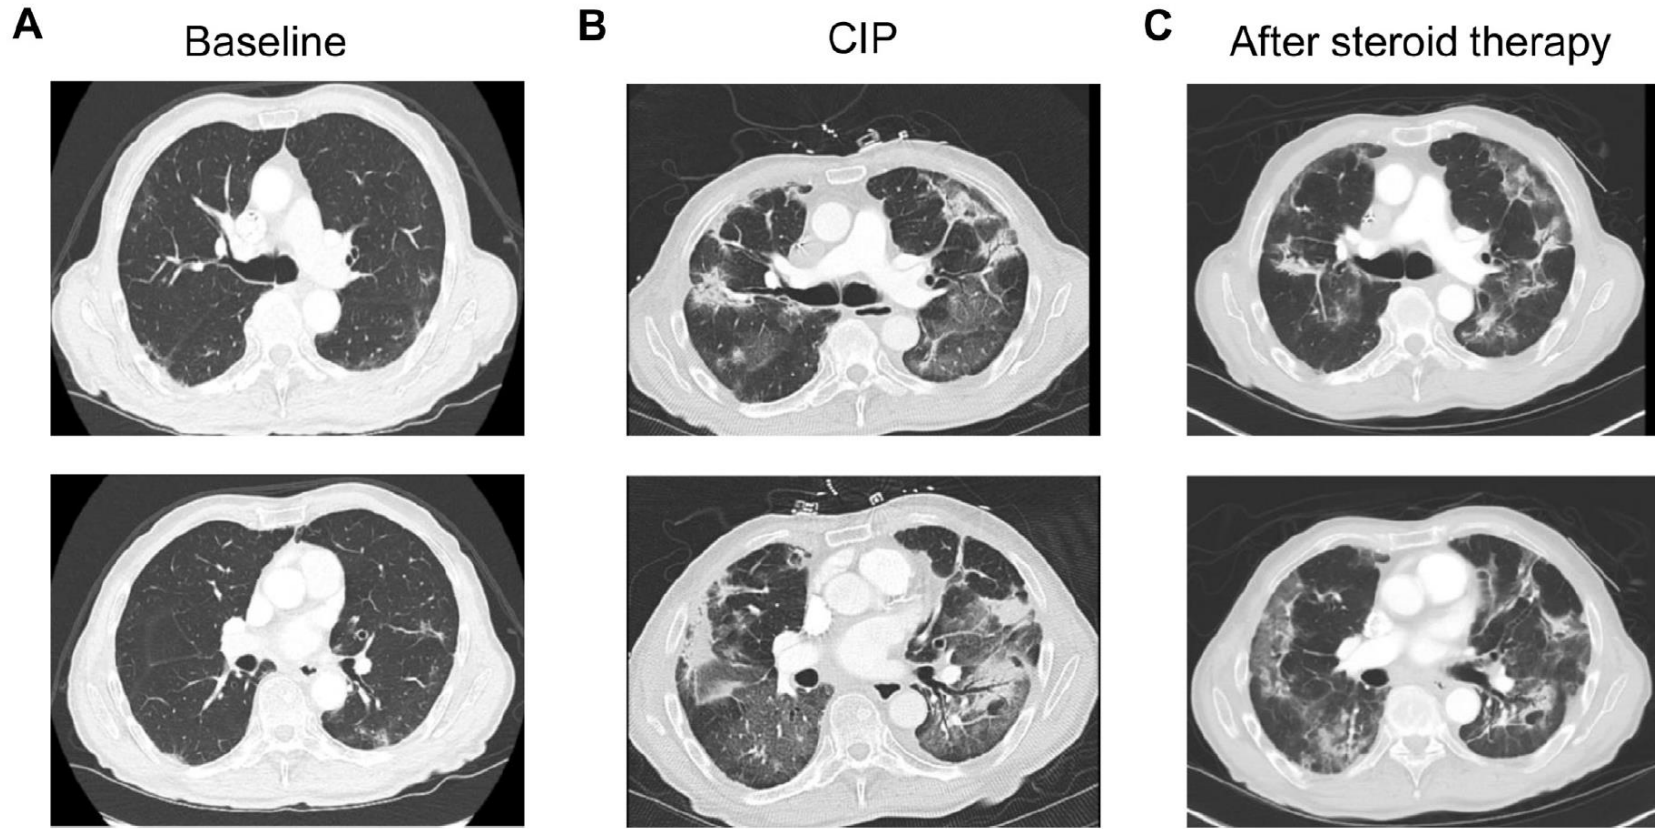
Representative computed tomography images from an immune checkpoint inhibitor-treated patient after initiation of immune checkpoint inhibitor therapy (A), at time of checkpoint inhibitor pneumonitis (CIP) diagnosis (B), and after 1 week of steroid therapy for CIP (C).
